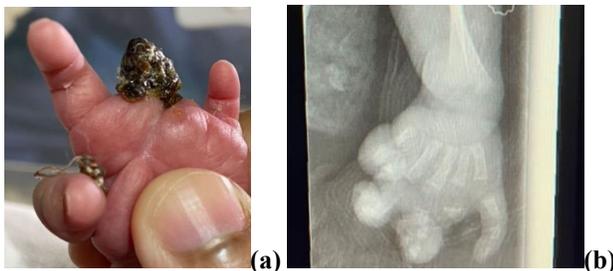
(a) middle and ring fingers dry gangrene with fibrous band. (b) radiograph left hand
